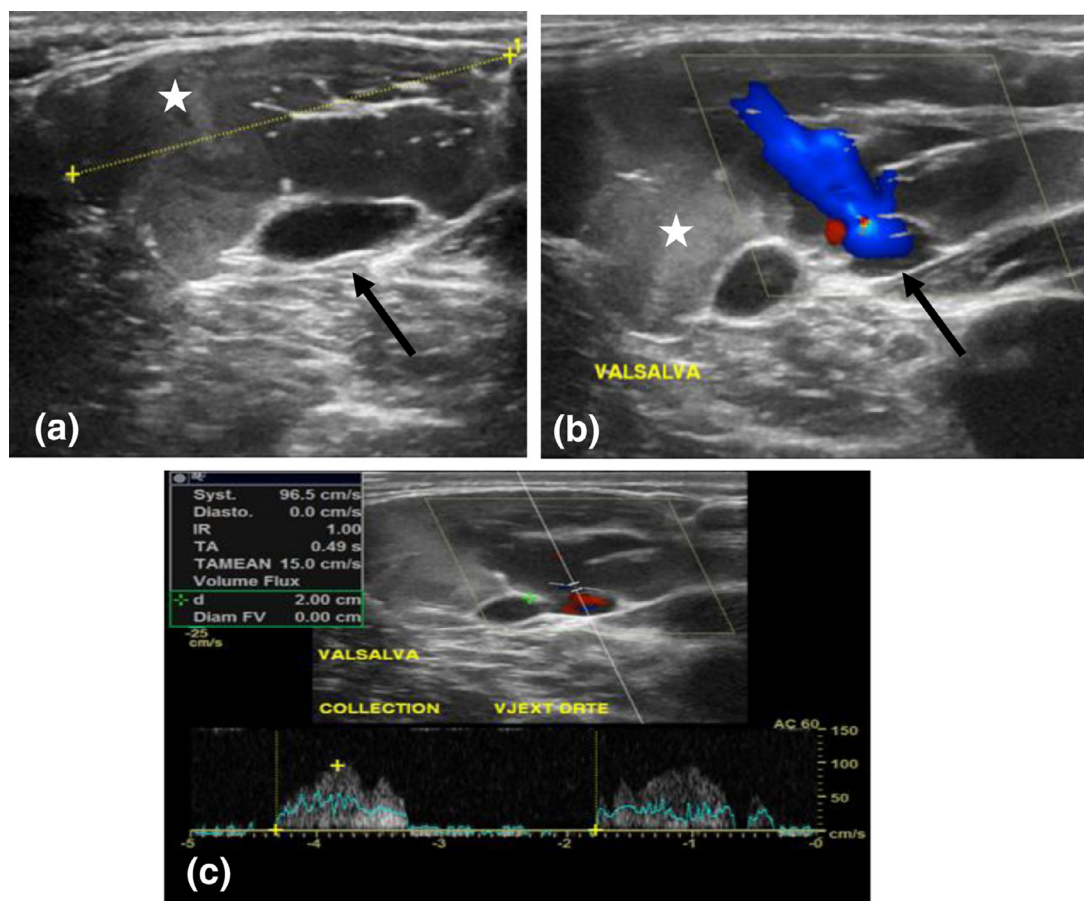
Color Doppler ultrasonography (a,b) reveals a wide-necked pseudoaneurysm of the right external jugular vein (Black arrow). The pseudoaneurysm sac is partially thrombosed (White star). Pulsed Doppler examination (c) of the neck of the pseudoaneurysm shows a typical to-and-fro waveform.
